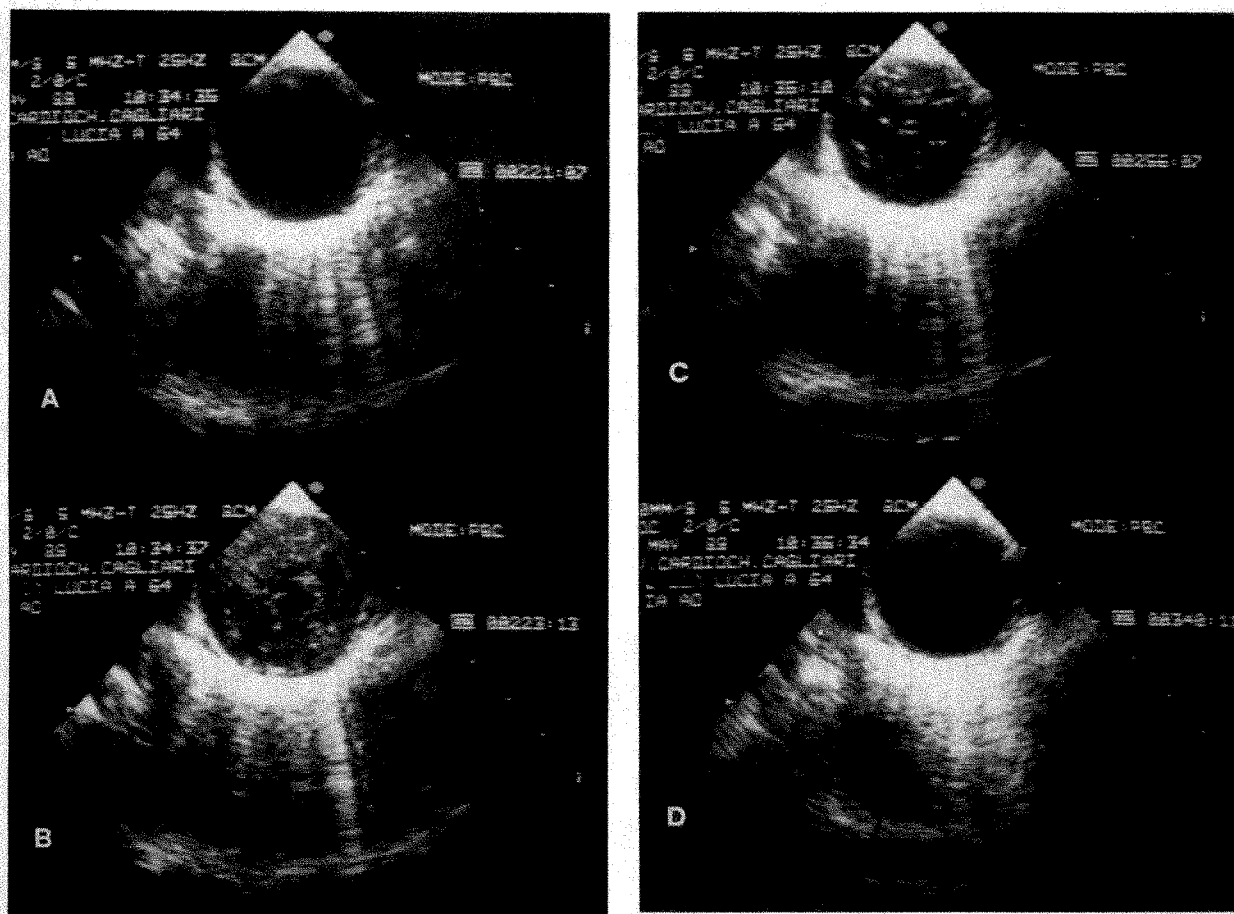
Hollow-fiber oxygenator. A, transesophageal cross-sectional view of descending aorta before start of cardiopulmonary bypass. B, echocardiographic contrast during infusion of priming solution at start of cardiopulmonary bypass. C, appearance of microbubbles during early phase of cardiopulmonary bypass. D, disappearance of microbubbles after early phase of cardiopulmonary bypass.
